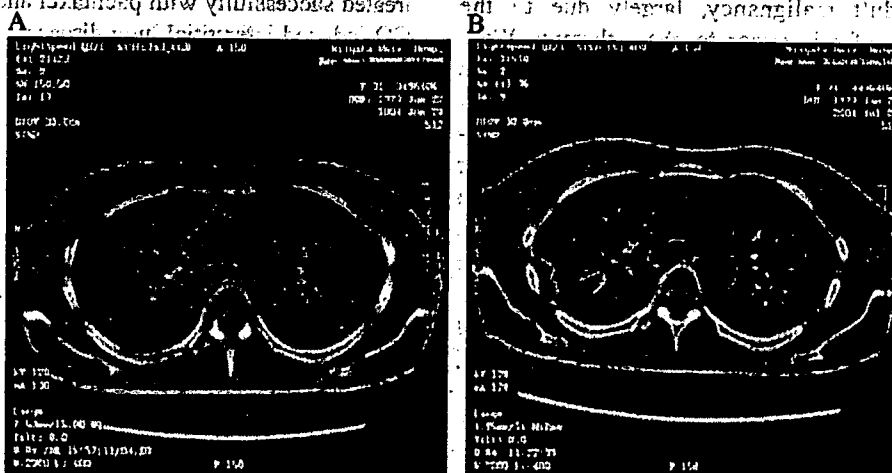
(A) Lung CT scan showed the extensive bilateral ground-glass opacity, and airspace consolidation. (B) After high-dose steroid therapy, ground-glass opacity on CT scan was remarkably improved.
